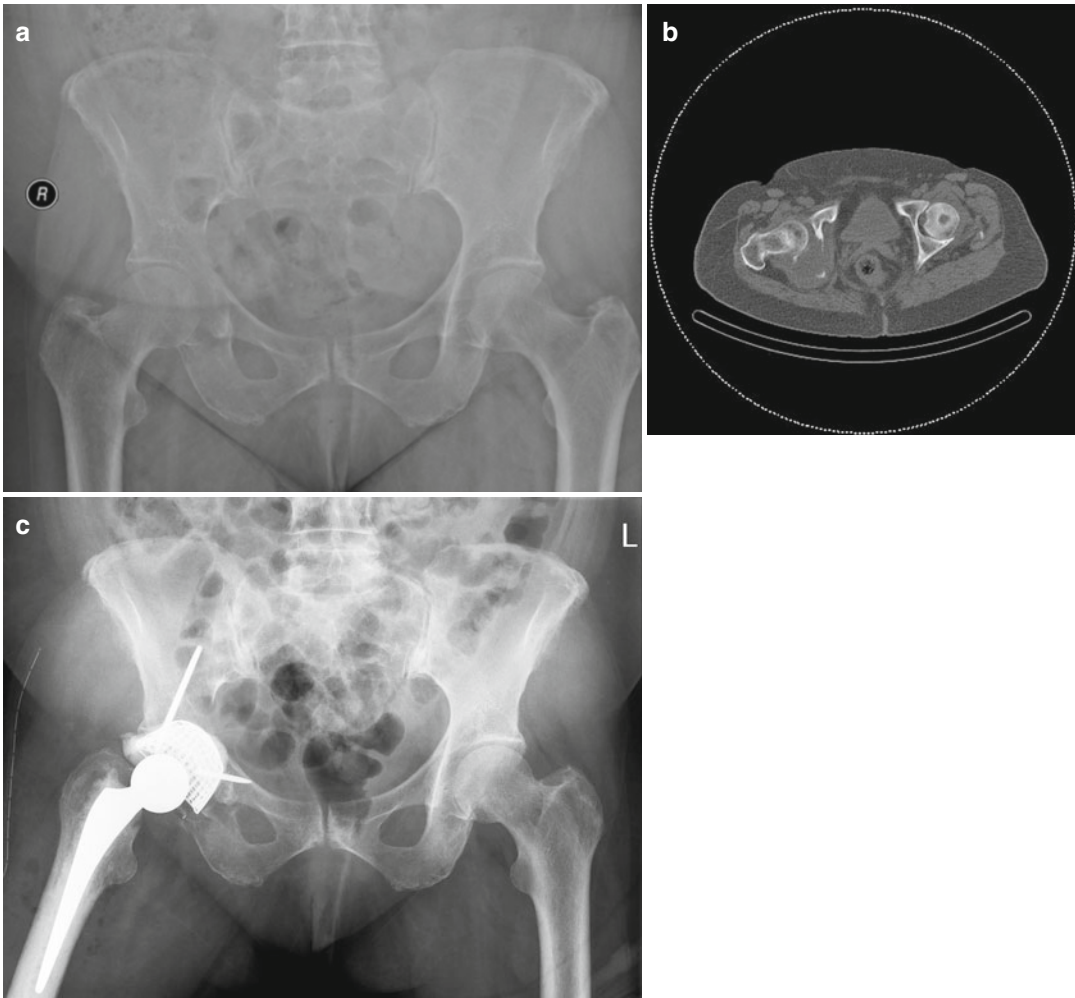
(a, b) Patient with MBD affecting the right hip secondary to lung cancer. Plain x-ray does not demonstrate the extent of the process. The CT better defines the deficiency of the posterior bone and joint penetration
